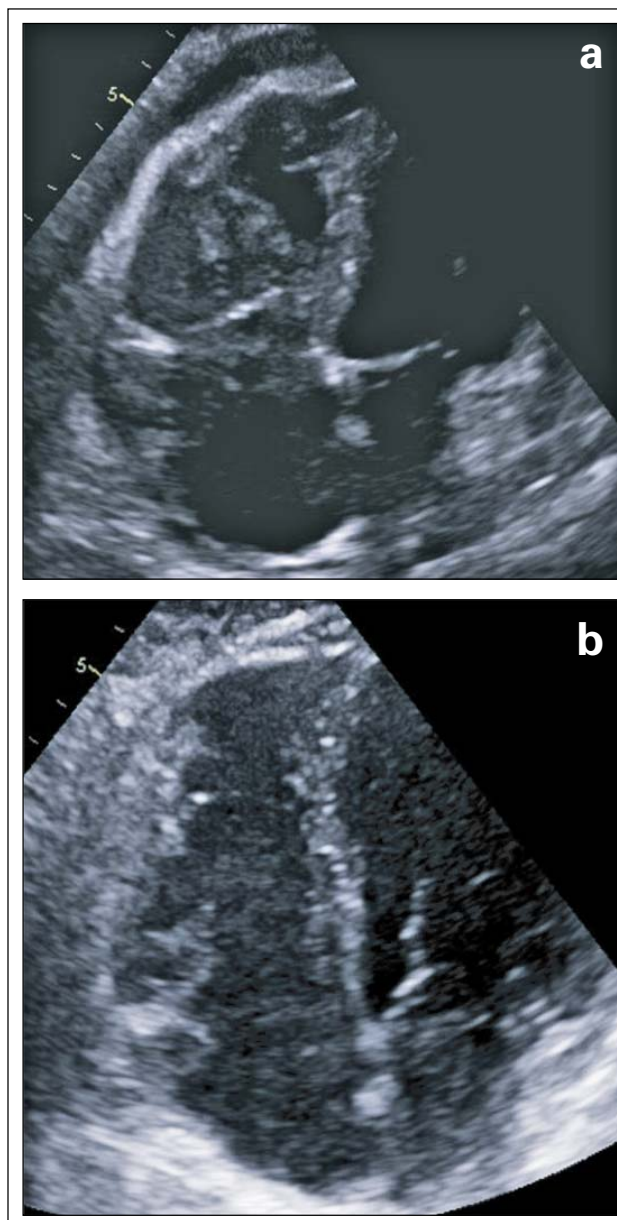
Transthoracic echocardiography before and after chemotherapy with reduced mass within 8 weeks.
